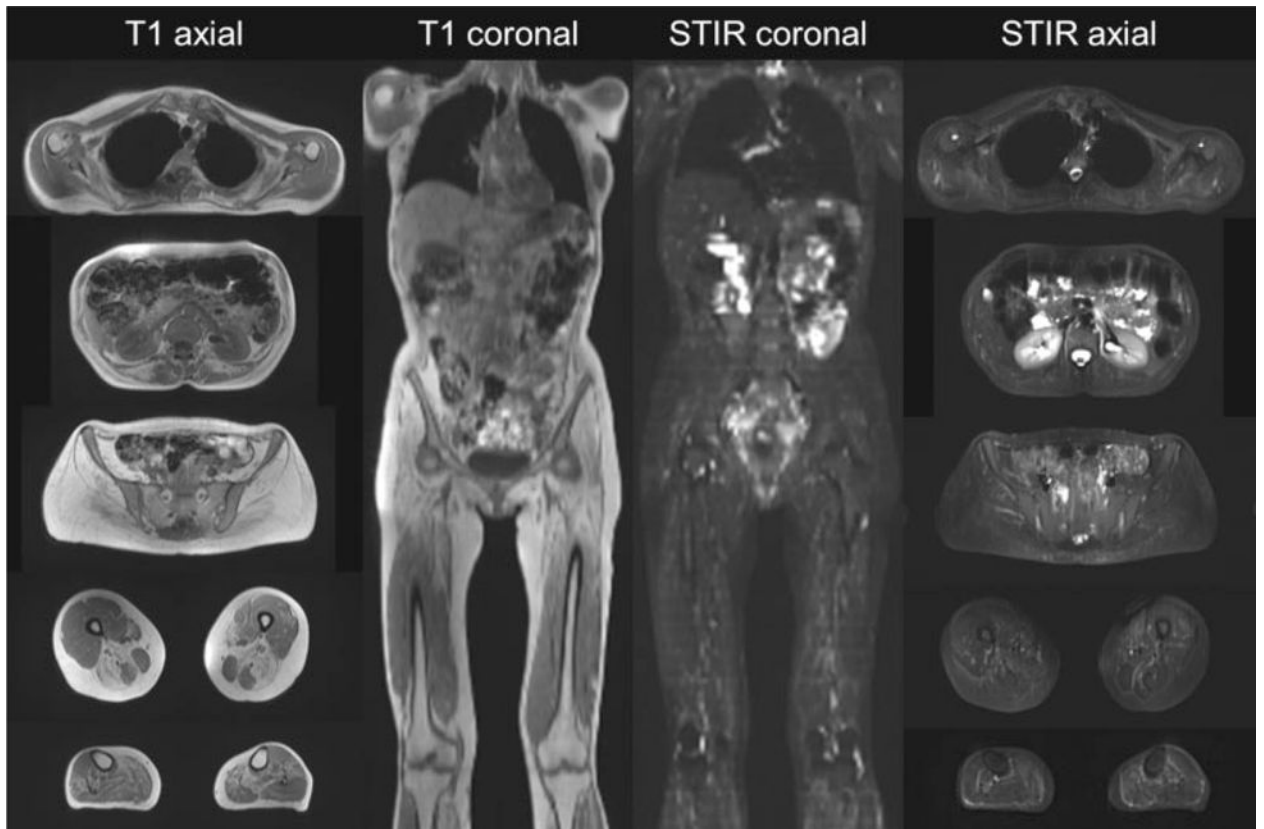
Representative examples of T1-weighted and short tau inversion recovery whole-body MR images in axial and coronal planes.
